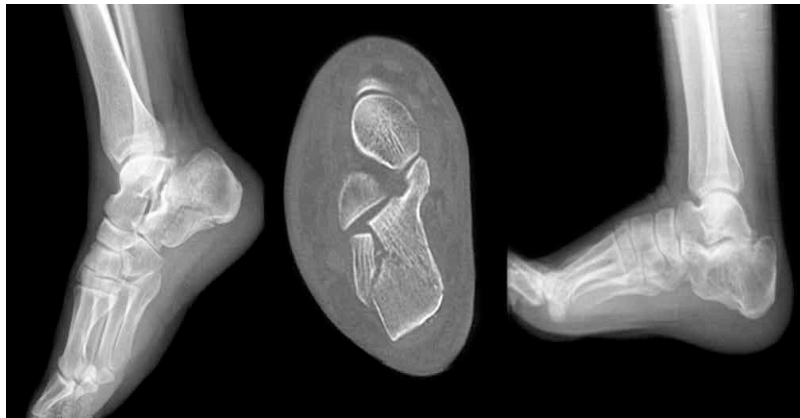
Initial lateral X-ray (a), computed tomography scan (b) and follow-up lateral X-ray (c) images of a conservatively treated patient
